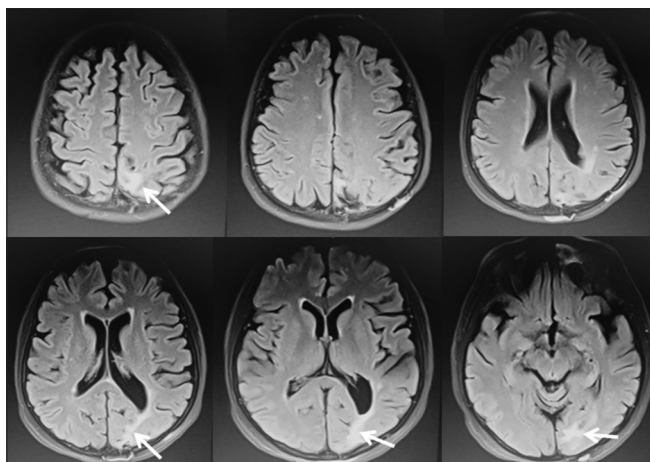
Cranial magnetic resonance imaging (flair sequences) showing encephalomalacia in the left occipital lobe
